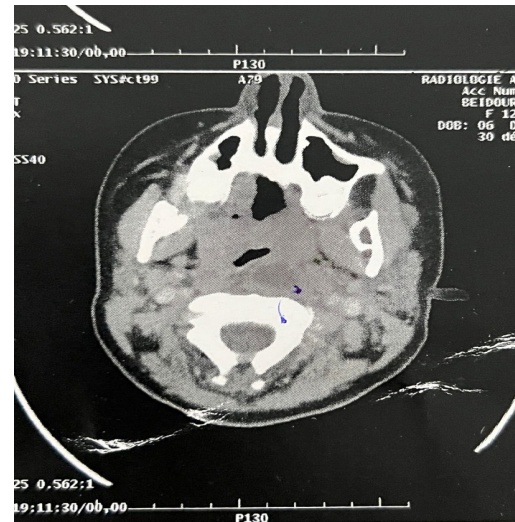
Initial cervical CT scan showing a necrotic left retropharyngeal lymph node.
